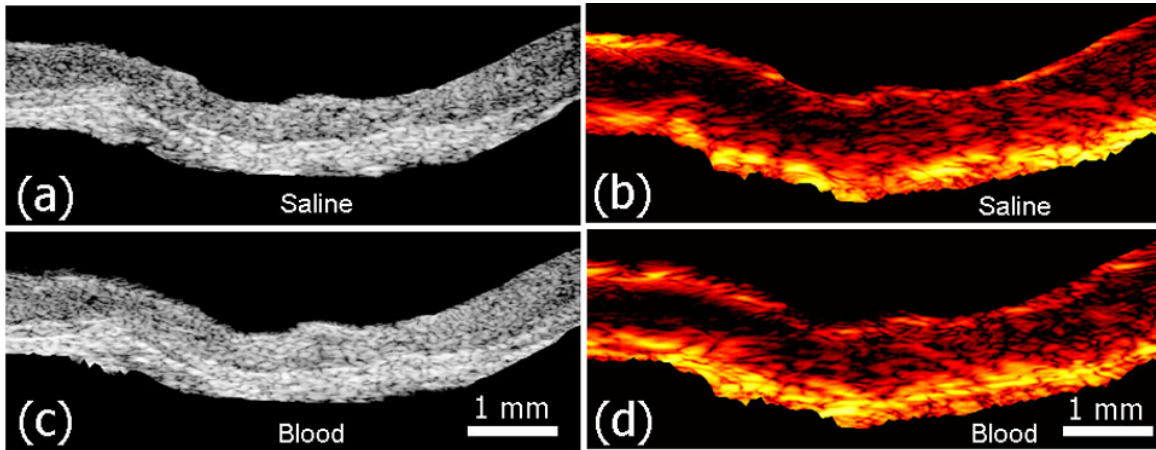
Ultrasound and photoacoustic image of the carotid artery with plaque immersed in (a-b) saline, (c-d) blood. The images were obtained at the same cross-section and measure 6.4 mm by 2.1 mm.
